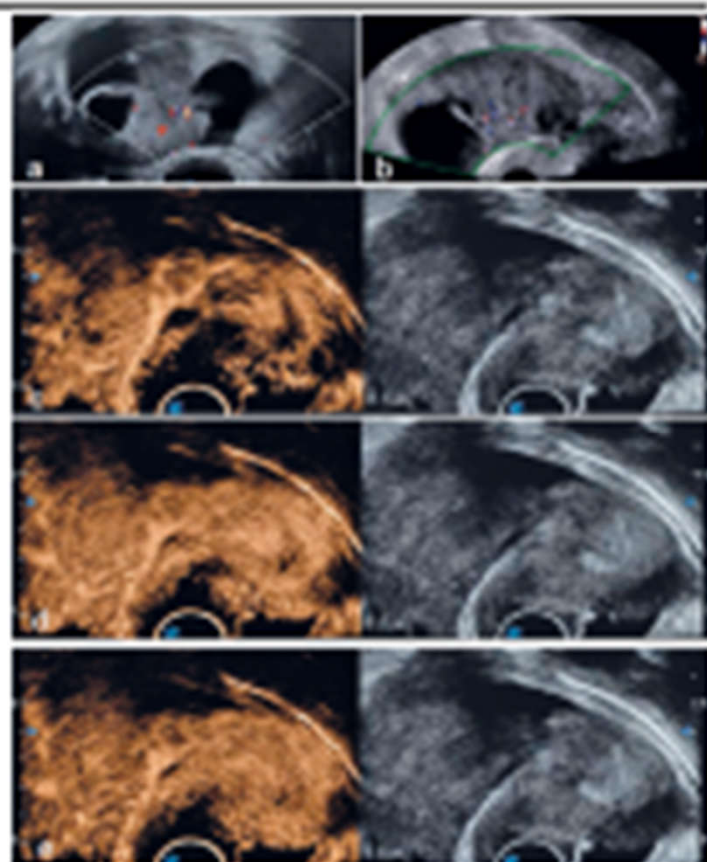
High-grade serous adenocarcinoma in a 67-year-old postmenopausal patient: Upgrading of O-RADS category by contrast-enhanced ultrasound. a, b: Conventional grayscale (a) and color Doppler (b) ultrasound images showed a large multilocular cystic-solid mass in the right adnexal region, initially classified as O-RADS 4; c-e: Transvaginal contrast-enhanced ultrasound (CEUS) sequences demonstrated characteristic malignant features: early enhancement (c), hypoenhancement (d), and early washout (e). This pattern resulted in a CEUS score of 6, prompting an upgrade to O-RADS category 5. The final pathological diagnosis was high-grade serous adenocarcinoma (Stage IIIA2).
